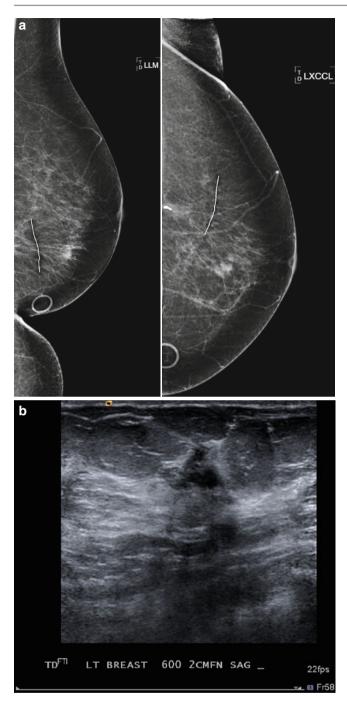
(a) A 72-year-old female status post left lumpectomy for DCIS 1 year prior. (b) Spot magnification views confirm a new mass in the posterior upper outer left breast. (c) A corresponding 8 mm solid mass is seen on ultrasound. Biopsy yielded invasive carcinoma
